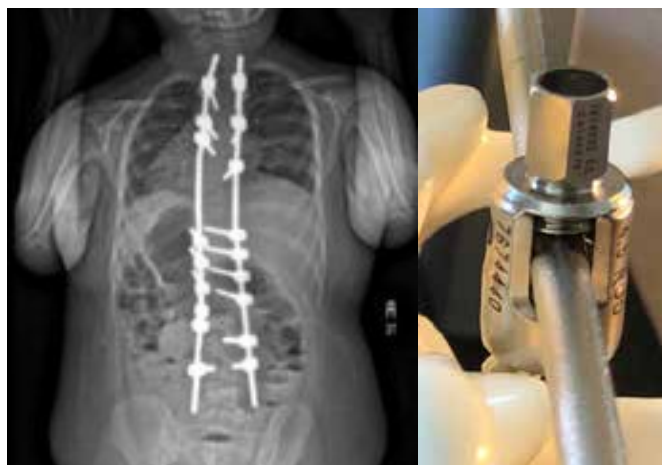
X-ray demonstrating Shilla hardware with fusion and pedicle screws in middle of spine and long rods at top and bottom so they can "grow with the spine".
